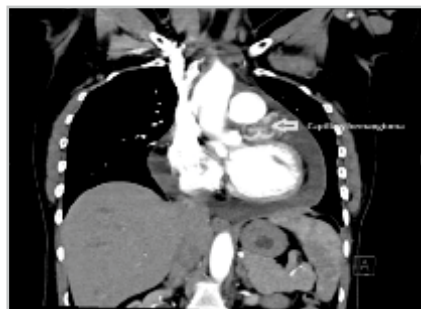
CT thorax shows mass attached to the main pulmonary artery and RVs
